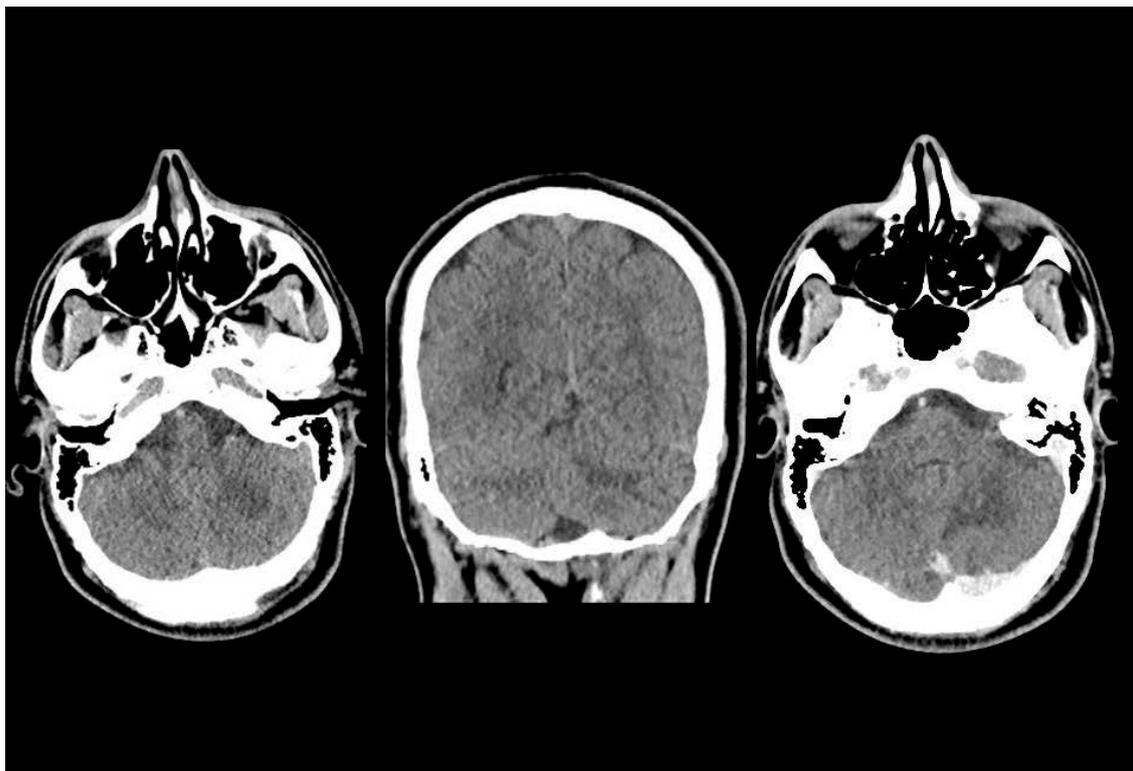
Follow up CT following craniotomy, evacuation of the abscess and antibiotics
